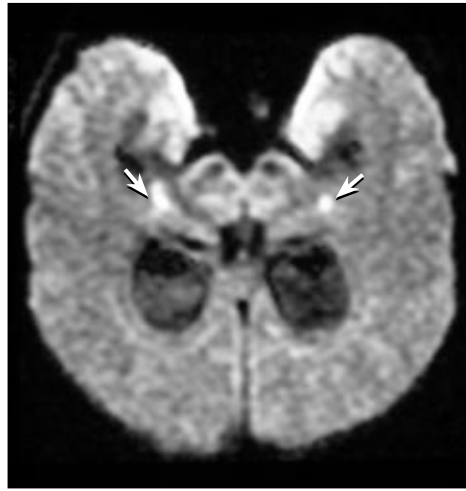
Axial diffusion-weighted MR images shows hyperintense signal in bilateral medial temporal lobes.
